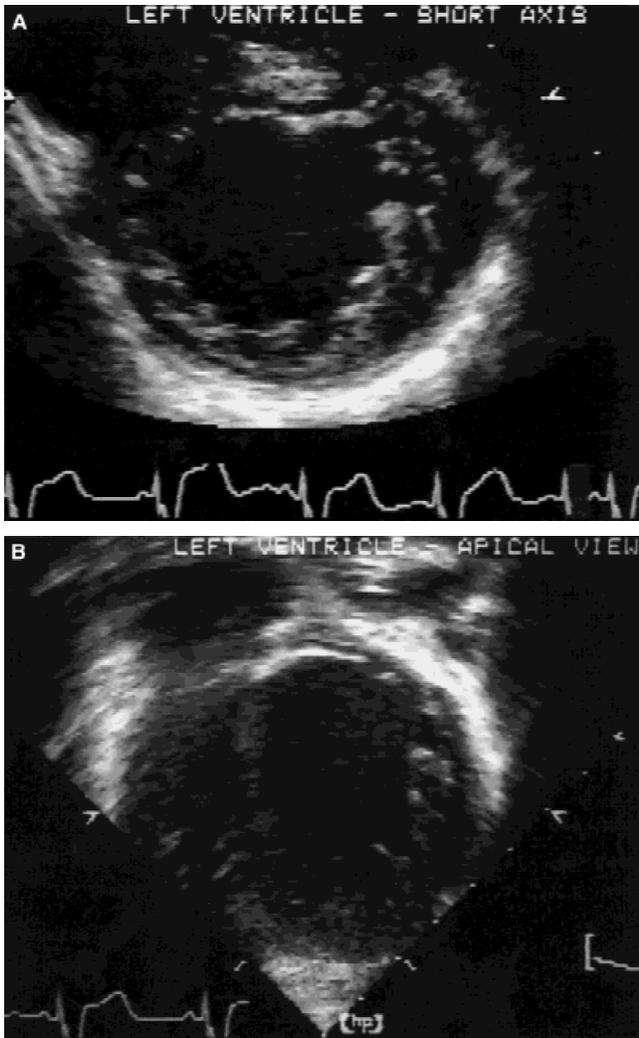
Echocardiography of the proposita. A: Left ventricle in short axis. Note the prominent, deep trabeculations and primitive appearance of the myocardium. B: Left ventricle in an apical, four-chamber view, again showing deep trabeculations and a primitive appearance of the myocardium.
